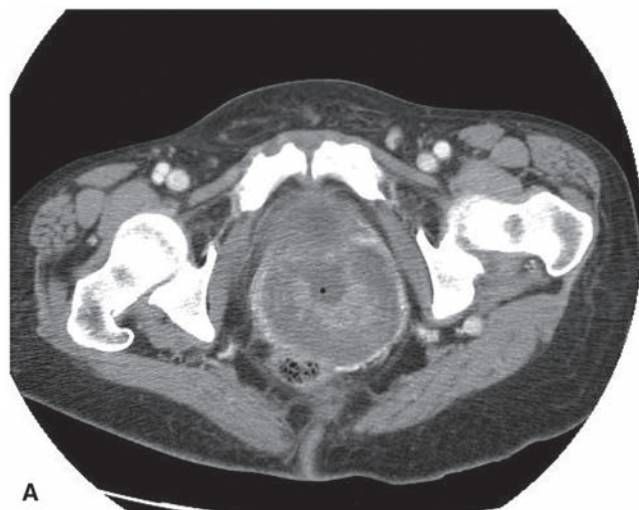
Palliative course of external beam irradiation using the RTOG 85-02 regimen. CT scan prior to initiation of therapy (A); AP (B) and lateral DRRs (C) of the initial fields; CT scan after 2 split courses of hypofractionated irradiation (2950 cGy) in 1 week (D). AP (E) and lateral DRRs (F) of the cone down fields prior to a brachytherapy boost; AP (G) and lateral radiographs (H) of the brachytherapy implant.
